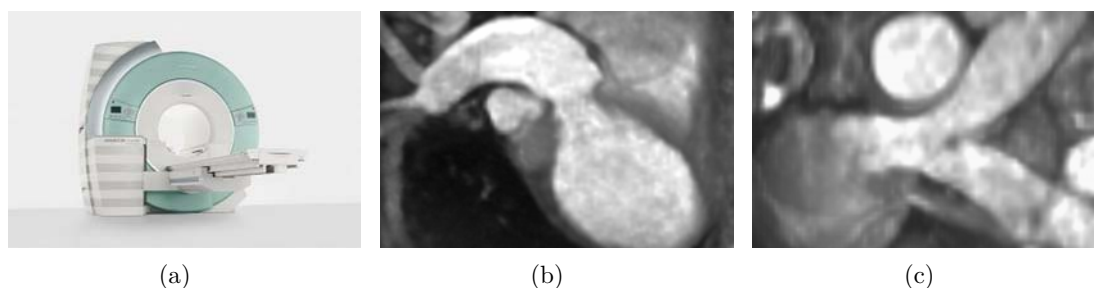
(a) MRI - Siemens Verio, Siemens Healthcare, Erlangen, Germany. (b) Heart image including the left ventricle and aorta. (c) Volumetric reconstruction of the right ventricular outflow tract and pulmonary arteries.
